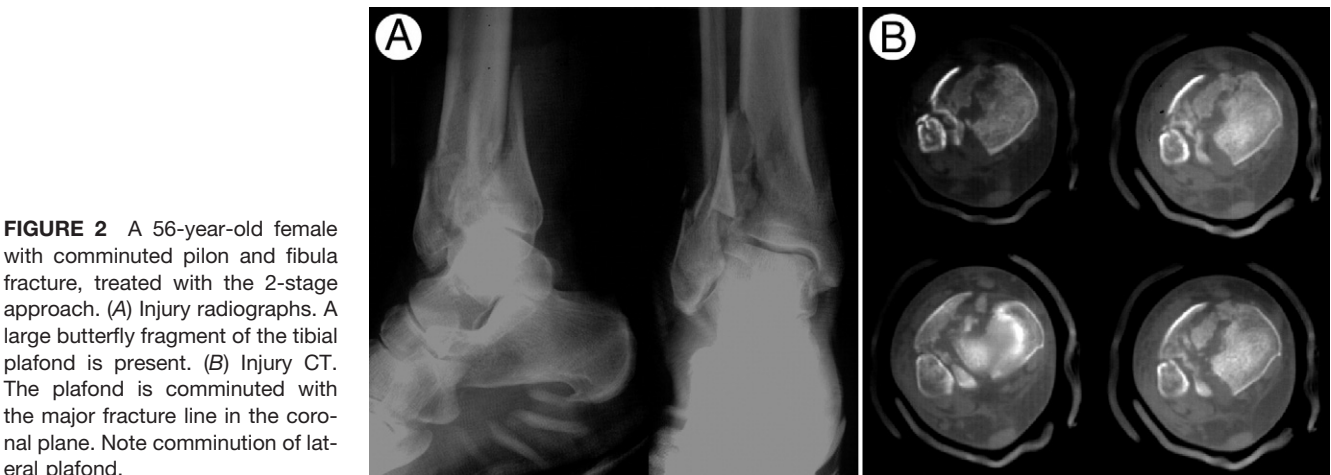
A 56-year-old female with comminuted pilon and fibula fracture, treated with the 2-stage approach. (A) Injury radiographs. A large butterfly fragment of the tibial plafond is present. (B) Injury CT. The plafond is comminuted with the major fracture line in the coronal plane. Note comminution of lateral plafond.
